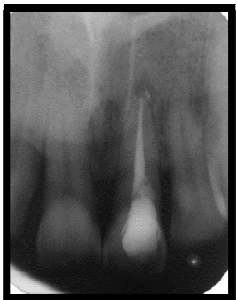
3 months follow-up radiograph of the tooth
